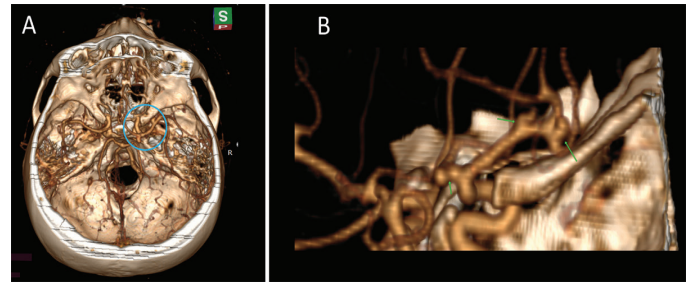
A 3D reconstructed cranial CTA. (A) Axial view, the location of the 3 aneurysms indicated by the circle. (B) Right oblique view, green arrows showing the aneurysms at A1, M1 and M2, respectively.
